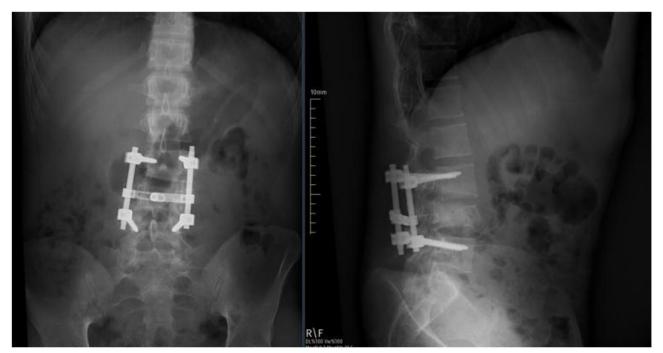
Post operative Xray images (AP and lateral view respectively) showing posterior L3 and L5 fixation and laminectomy of L4.
